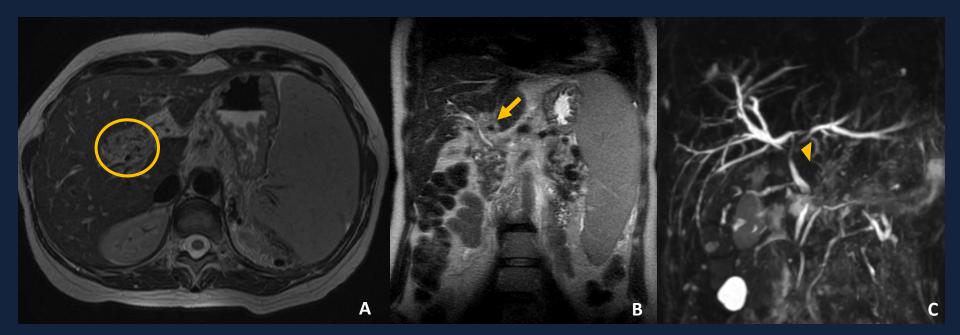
36-year old female with a known hypercoagulability condition (JAK2+) and portal cavernoma. T2-weighted axial (A) and coronal (B) MR images, show a serpiginous cavernoma (circle) with consequent extrinsic compression of common biliary duct (arrow). MRCP (C) images demonstrate stenosis of the main biliary duct at the hilar level (arrowhead) with consequent right and left biliary branches dilatation.
